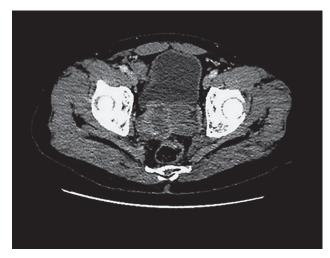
Axial computed tomography scan showed a prostate heterogeneous mass with hypodense areas suggesting contextual necrosis.
